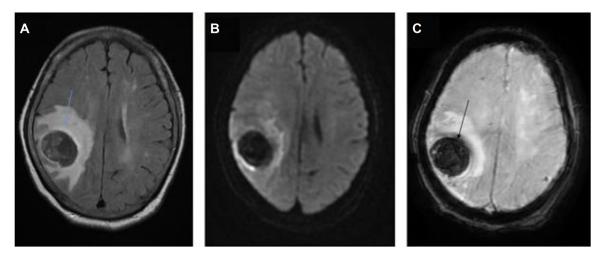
Gerebral MRI showing an intraparenchymal right parietal cerebral hematoma (black arrow) with perilesional vasogenic edema (blue arrow).
